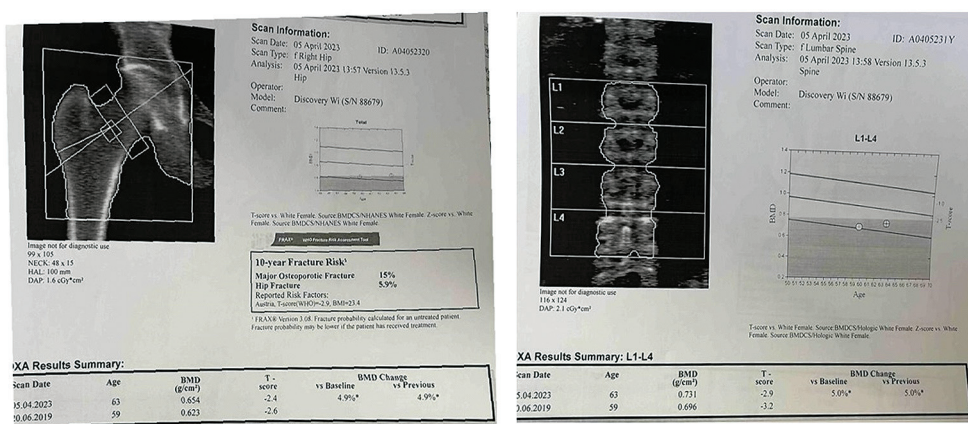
Dual X-ray absorptiometry follow-up of the total hip and the lumbar spine
